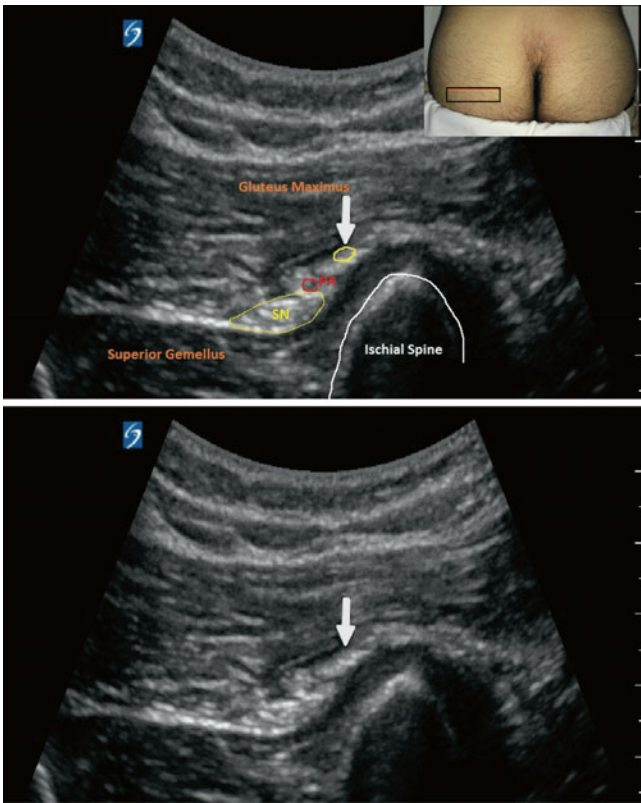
Ultrasound image of the pudendal nerve. SN sciatic nerve, PA pudendal artery; white arrow pudendal nerve (Image courtesy of Agnes Stogicza, MD)
